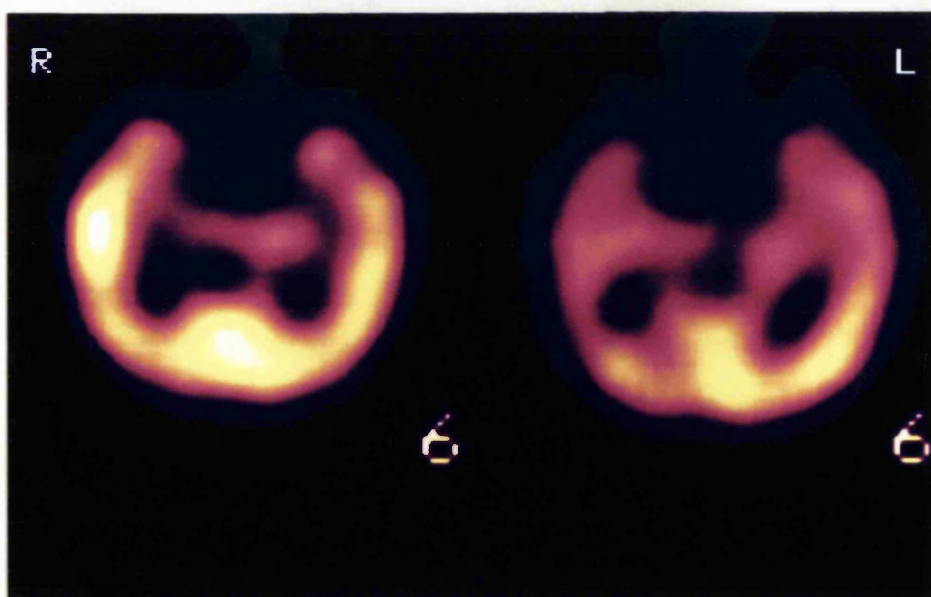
Coronal sections perpendicular to the temporal lobe, T2 weighted sequence MRI (A), and  $^{99}\text{Tc}^{\text{m}}$  HMPAO SPECT scans (B) of patient T34. MRI shows foreign tissue lesion of the right mesial temporal region (microdysgenesis at pathology). Postictal SPECT shows hyperperfusion of the right temporal region.
